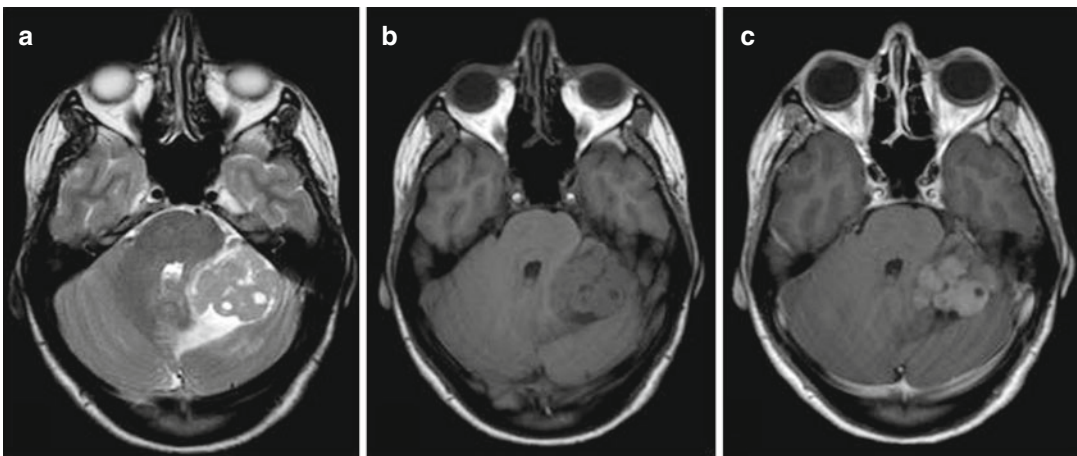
Medulloblastoma. Axial MRI of an adult medulloblastoma in left cerebellar hemisphere shows a relatively dishomogeneous mass (a) in T2 sequences, with moderately intense contrast enhancement after contrast medium (c)
